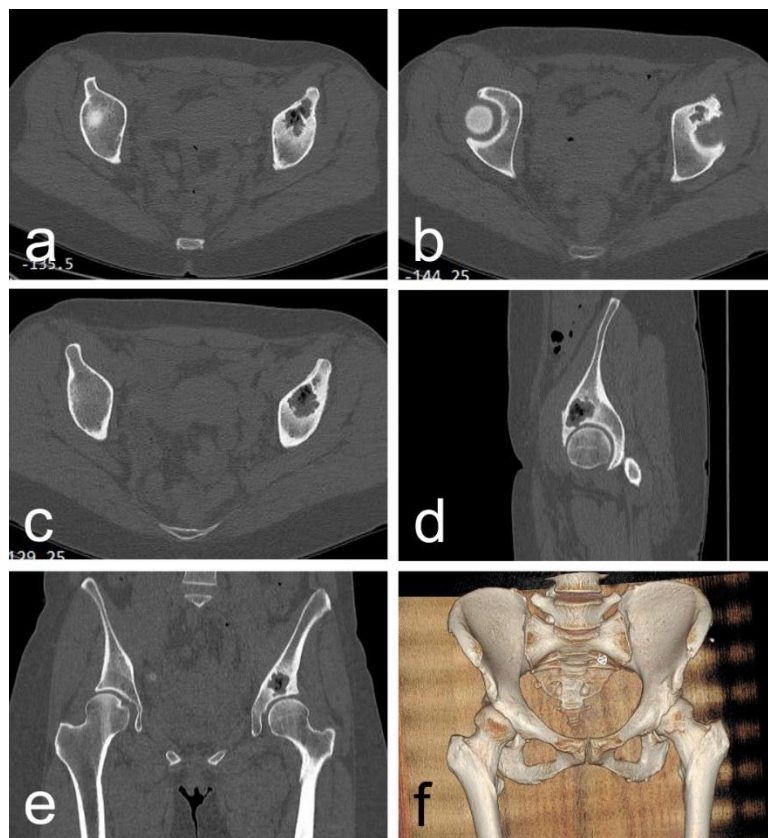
Preoperative CT
